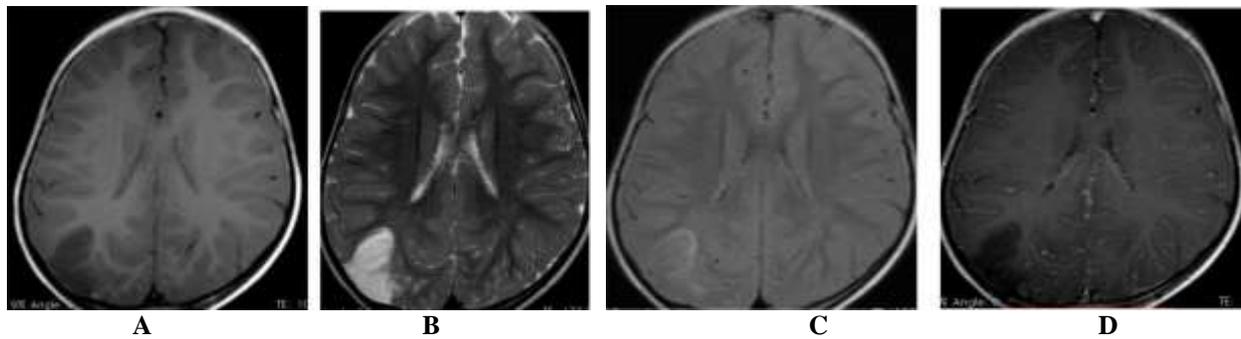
(A-D) Dysembryoplastic neuroepithelial tumour in a 4 year old male. Images showing a multilobulated cystic lesion involving the right posterior parietal cortical-subcortical region appearing hypointense on T1 weighted (A) and hyperintense on T2 weighted (B) with a perilesional hyperintense rim on FLAIR (D) and no postcontrast enhancement (E).
